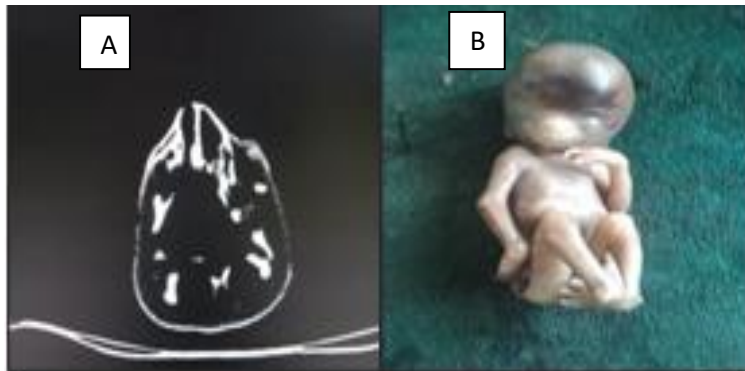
Edward Syndrome (A) CT Scan showing Hypoplasia of nasal bone (B) Pointed frontal bones and flat occiput, shield chest, rocker bottom foot.
